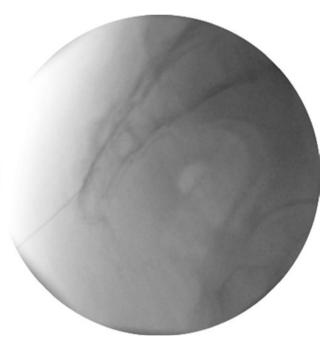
Nonionic radiographic contrast confirming proper placement
